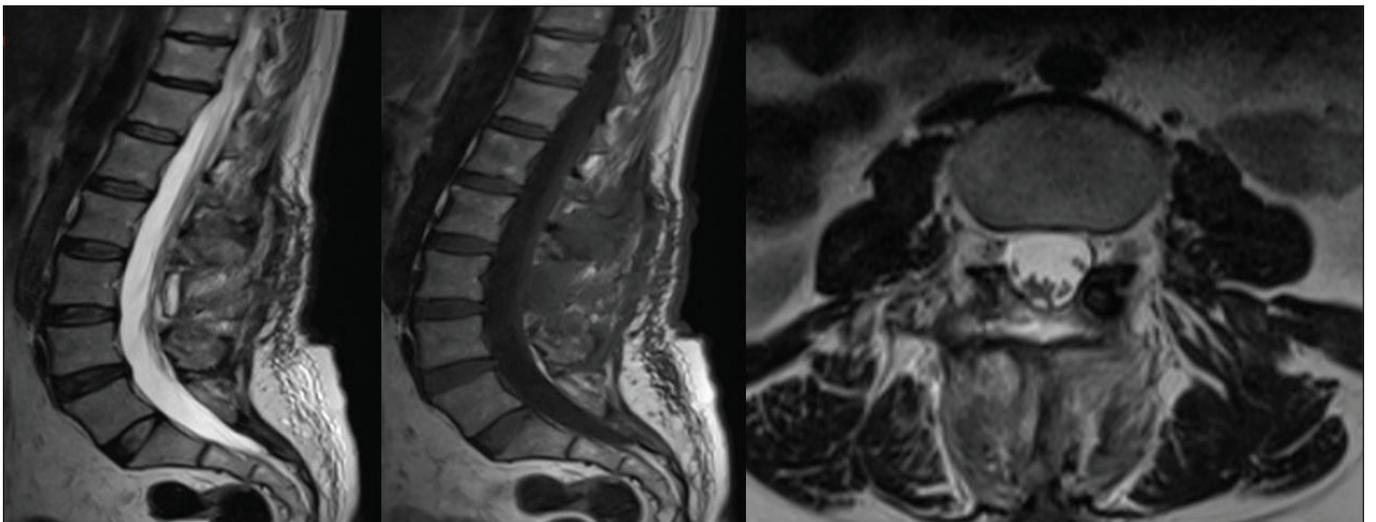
Postoperative sagittal and axial MRI of the patient.
